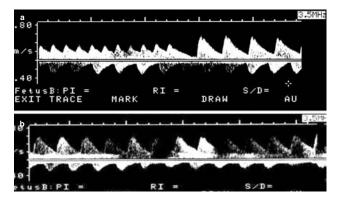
Ultrasound scans of monochorionicmonoamniotic twins at 24 weeks. Blood flow waveforms obtained from the mass of cord vessels show two different heart rates, suggesting two various umbilical cords. This is especially evident in case (a) where one fetus presented signs of supraventricular tachycardia with periodic return to the normal rhythm
